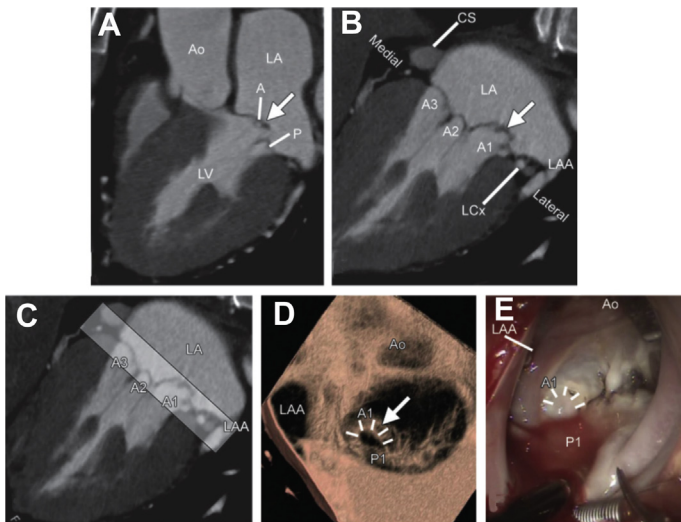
Reconstruction of CT images of the MV to evaluate the extent and location of MV prolapse. A1, A2, and A3 = lateral, middle, and medial scallops of the anterior leaflet, respectively; P1, P2, and P3 = lateral, middle, and medial scallops of the posterior leaflet, respectively. Parasagittal reconstructed CT image shows MV prolapse in the A1 portion (A). A coronal reconstructed CT image shows a prolapsed scallop of the MV (arrow) near the left atrial appendage, which is a landmark of a lateral direction in the MV annulus. The proximal left circumflex artery (LCX) is also located in the lateral direction, and the coronary sinus (CS) and interatrial septum are located in the medial direction (B). Coronal thin-section maximum intensity projection reconstructed CT image obtained at the level of the valve shows the section thickness used to generate the surgeon's view (C). Surgeon's view of the MV obtained with thin-section (15-mm) volume rendering shows that the A1 scallop is prolapsed (D). Intraoperative photograph obtained with a robot-assisted surgery system shows that the locations of the prolapsed scallop and left atrial appendage (LAA) correspond with the CT findings (E). Ao, ascending aorta. (From Koo HJ, Yang DH, Oh SY, et al. Demonstration of mitral valve prolapse with CT for planning of mitral valve repair. *Radiographics*. 2014;34(6):1537-1552; with permission.)
